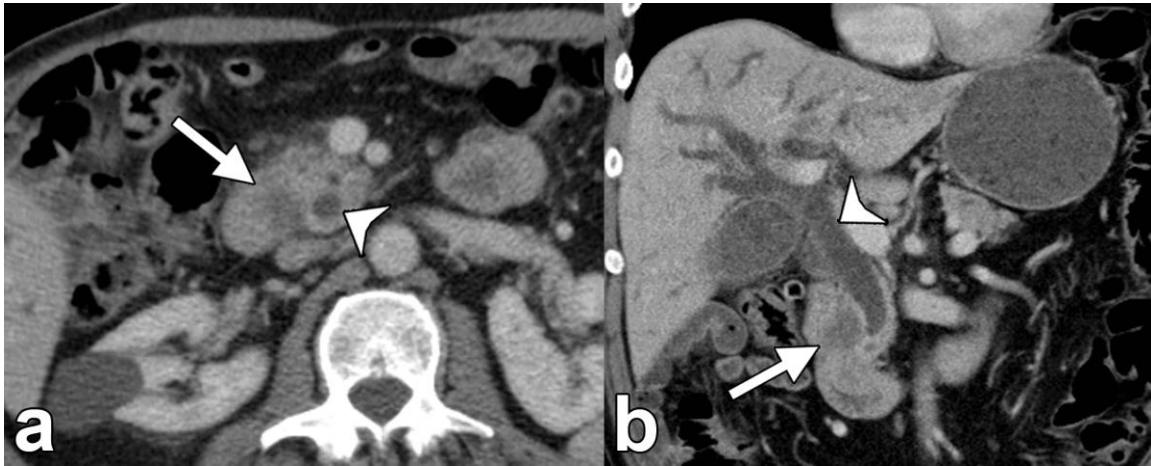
Example of a true positive CT examination. A 69 year-old man underwent uniphasic contrast-enhanced CT for evaluation of painless jaundice. (a) Axial and (b) coronal images show a 2.2 cm ill-defined hypoattenuating mass in the pancreatic head (arrows). There is obstruction of the common bile duct (arrowheads) and pancreatic duct (not shown). Imaging findings were interpreted as consistent with pancreatic adenocarcinoma.
